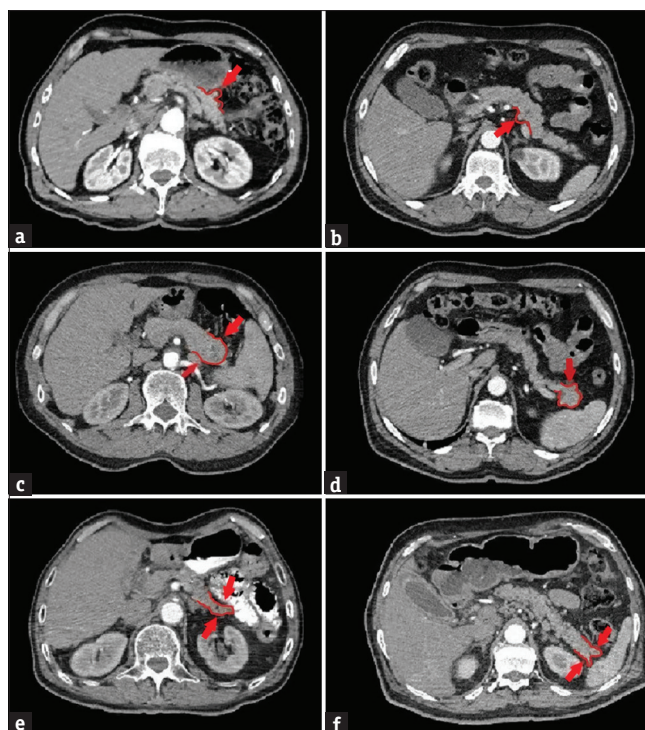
The axial computed tomography sections demonstrate contour variations in the pancreatic tail (a) Type Ia, (b) Type Ib, (c) Type IIa, (d) Type IIb, (e) Type IIc, (f) Type IIId
